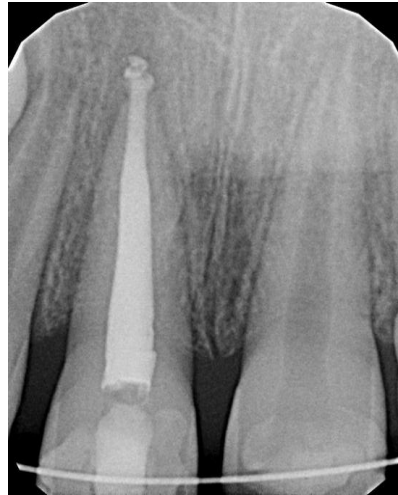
Post-operative intraoral periapical radiograph taken after 30 days, to ascertain alignment of tooth and apical positioning
